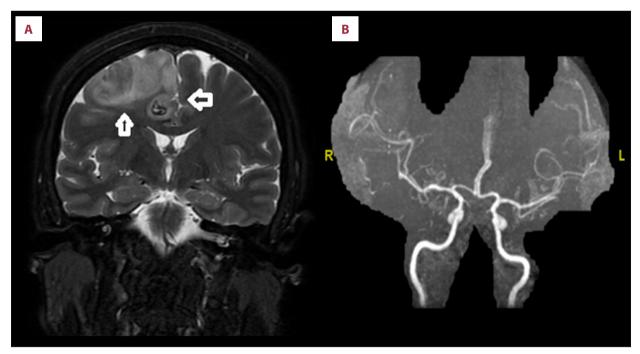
(A) Coronal section of T2-weighted MRI image shows infarct (white arrows) with areas of mosaic hemorrhage in right parietal region, (B) MR angiogram showing a patent arterial system.
